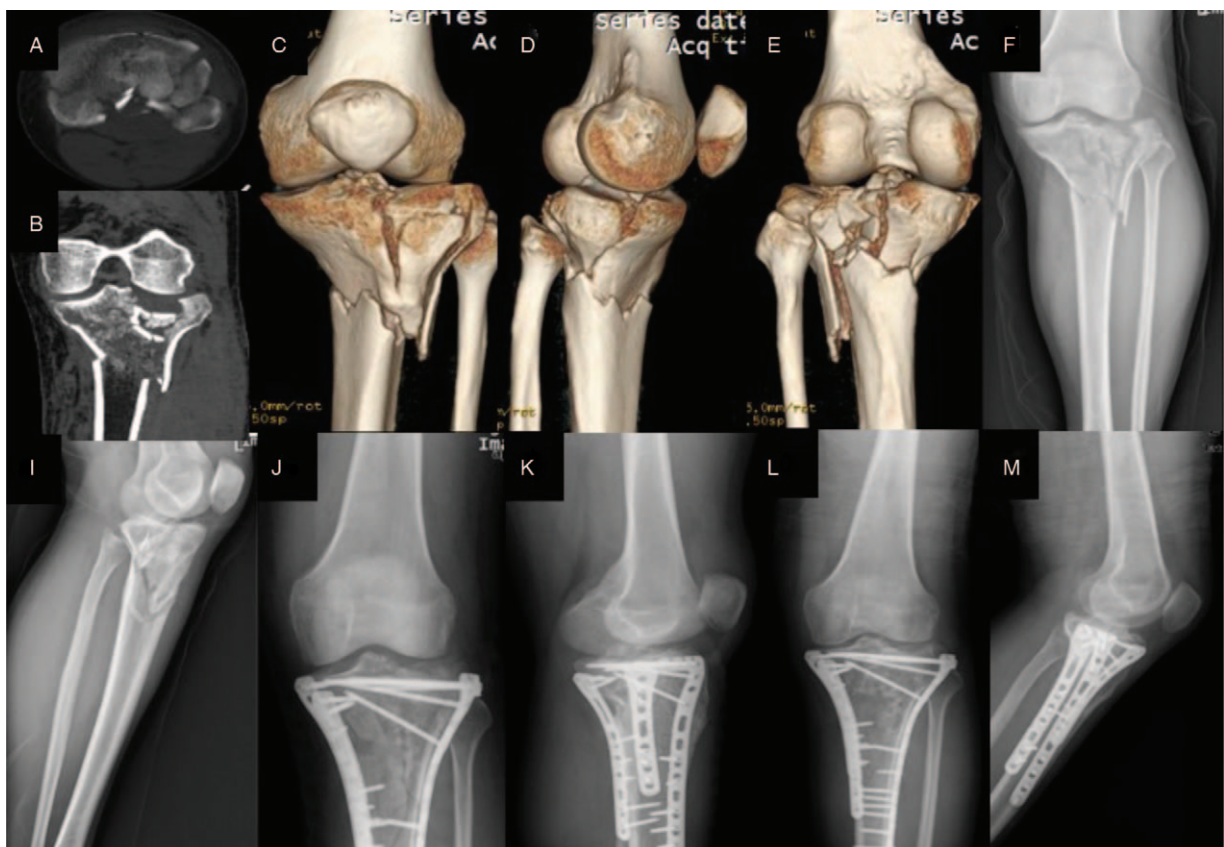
A male Schatzker type VI patient, 47 years old, with a left tibial plateau fracture (Schatzker type VI) due to a traffic accident injury. Pre-operative X-ray and CT reconstruction showed that the fracture line involved the medial, lateral, and posterior 3 columns (A–I). The extended anterolateral combined with a medial approach involved L-shaped locking compression plate plus medial locking compression plate fixation. Immediate postoperative X-ray (J, K) showed that anatomical reduction was achieved. Twelve months after the operation X-ray (L, M), the fracture healed well, the fracture line was blurred, and articular reduction was still maintained. CT = computed tomography.
